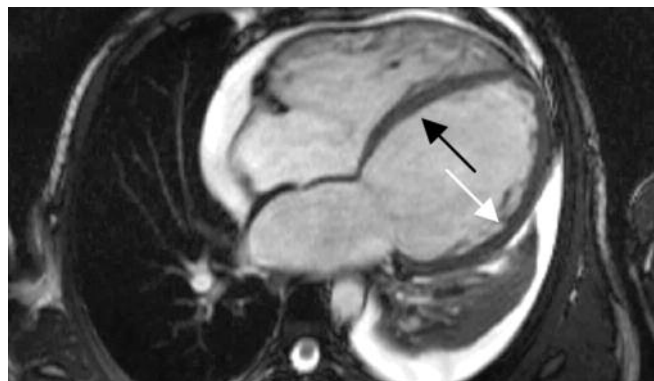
Cardiac MRI showing a severely dilated left ventricle (arrows outlining the septal [black] and lateral walls [white]) with an ejection fraction of 31% in keeping with severe left ventricular systolic dysfunction. On the delayed contrast images there were no features of infarction, scar or active inflammation.
